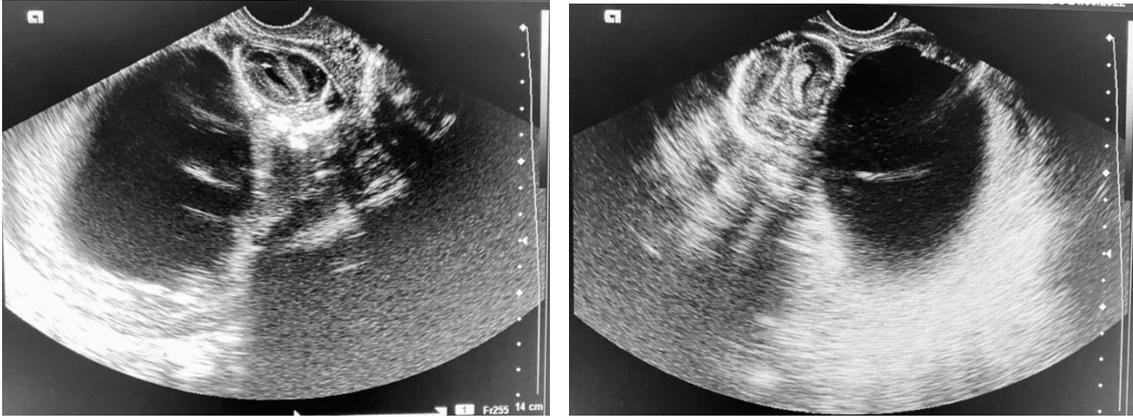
Antenatal ultrasound showing fetal head and compressed thorax in close approximation to the placenta with large amniotic sac with polyhydramnios.
